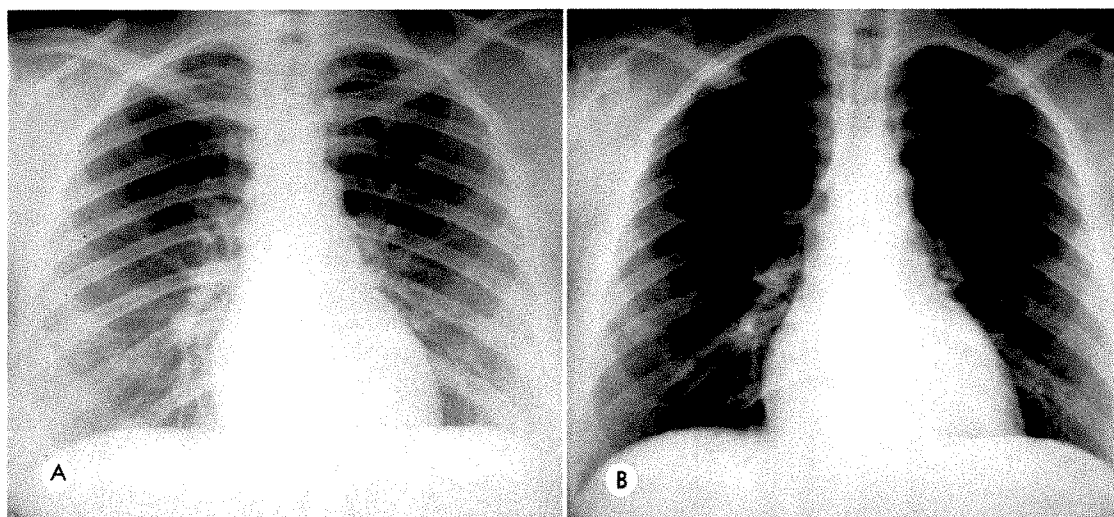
(*A*) Conventional chest roentgenogram of a woman with adipose breasts. (*B*) With an increase in kilovoltage, the breasts and overlying bone structures are adequately penetrated but the apical regions are overpenetrated.
